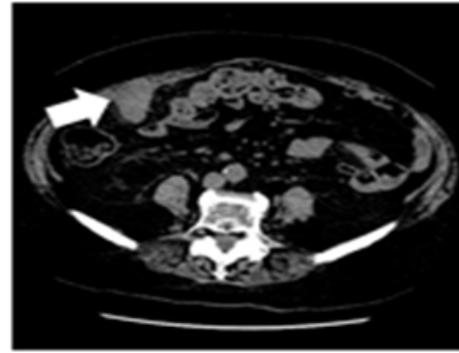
A contrast-enhanced CT scan of the abdomen obtained at 9 months after surgery recurrent peritoneal dissemination was detected (white arrow).
